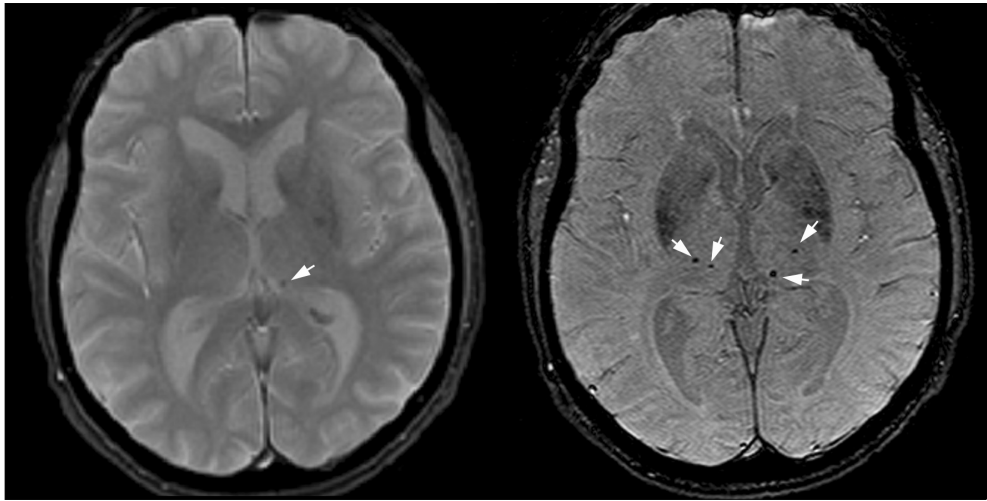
Microbleeds on 3D T2*GRE imaging compared with conventional 2D T2*GRE imaging. Axial MR images obtained with conventional 2D T2*-weighted GRE (left) (repetition time ms/echo time ms, 775/20; flip angle, 25°; section thickness, 5 mm) and accelerated 3D T2*-weighted GRE (right) (45/31; flip angle, 13°; section thickness, 1.6mm zero-padded to 0.8 mm) sequences in the same participant. More cerebral microbleeds (arrows), seen bilaterally in the thalamus region, are visible on the 3D T2*-weighted GRE image than the 2D T2*-weighted GRE image.
